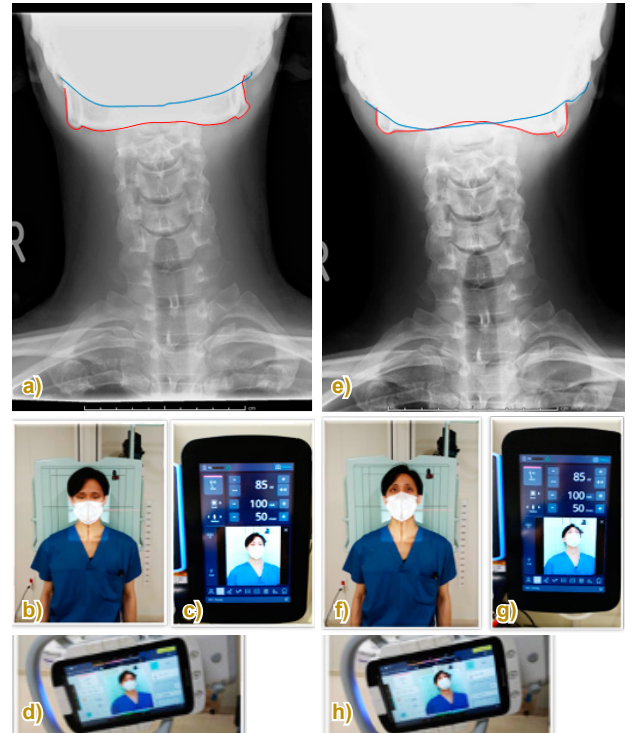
Frontal cervical spine radiography. a), b), c), and d) are from the initial radiography; e), f), g), and h) are from the retake. a) X-ray image. b) Patient position (recreated). c) Last Position Display image shown on the X-ray control console (recreated). d) Last Position Display image shown on the X-ray tube support (recreated). e) X-ray image from the retake. f) Readjusted patient position (recreated). g) Camera image shown on the X-ray control console (recreated). h) Camera image shown on the X-ray tube support (recreated).
